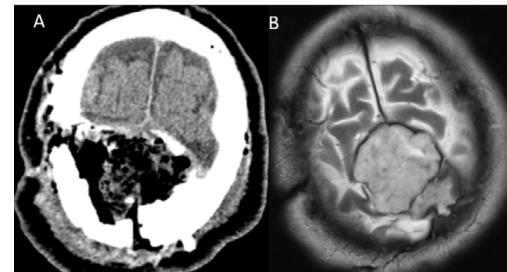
Preoperative CT axial (A) and Postoperative T2-weighted MRI axial (B).
